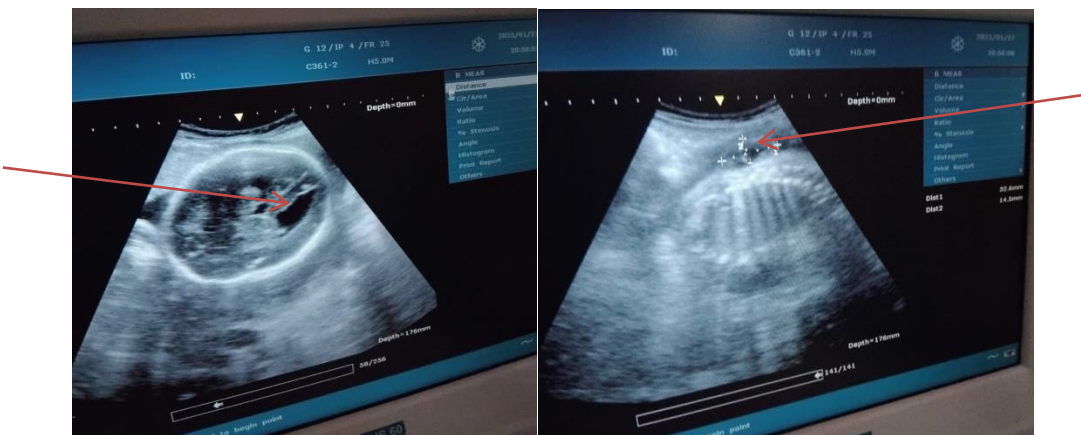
Ultrasonographically detected ventricular and spinal defects of fetus in 25 years old multigravida pregnant woman at 31 weeks of gestation in Mekelle general hospital, 2025.
